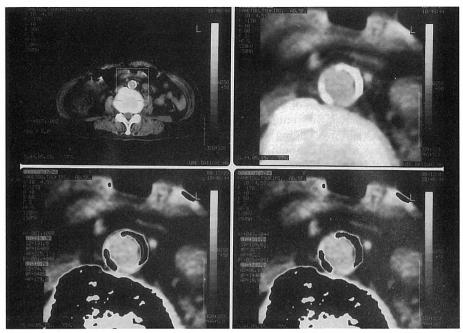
Measurement method of abdominal aortic calcification by computed tomography (CT).
